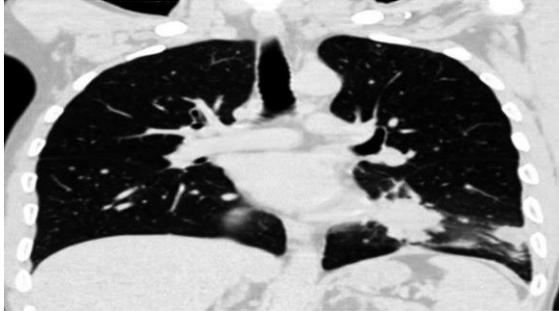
Chest contrast CT scan showing the tumor in the left lung (Turliuc *et al.*, 2015).
